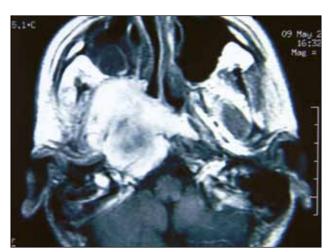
T1 weighed contrasted MRI views, homogenous contrasted parapharyngeal mass invading right TMJ with extension to the right anterior pontoserebellar region is seen (axial).
